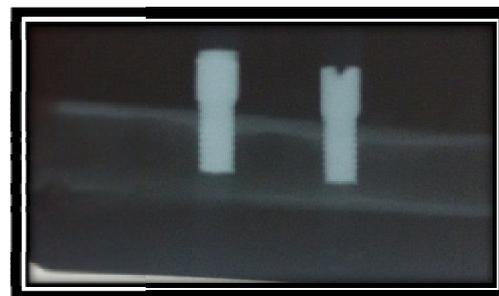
Radiographic view showed nano coated implant 6 weeks post implantation
